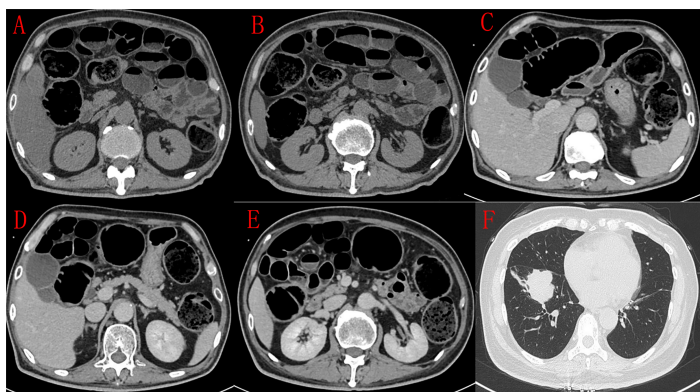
A-E: Abdominal computed tomography (CT) showed bowel distention; F: Lung CT showed right lung space-occupying lesions.
